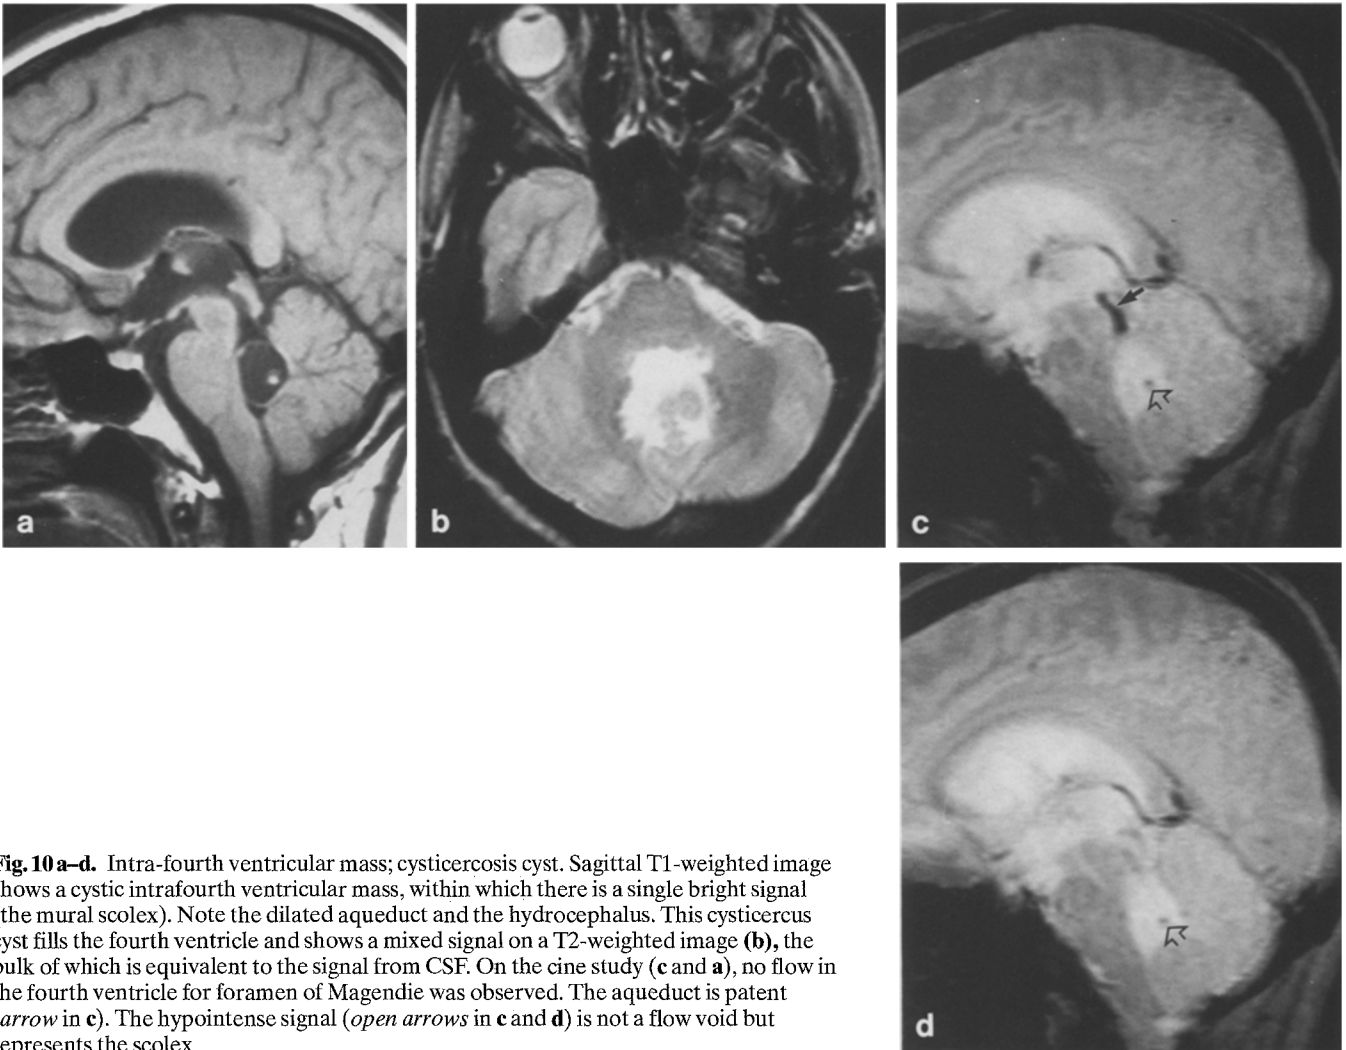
a–d. Intra-fourth ventricular mass; cysticercosis cyst. Sagittal T1-weighted image shows a cystic intrafourth ventricular mass, within which there is a single bright signal (the mural scolex). Note the dilated aqueduct and the hydrocephalus. This cysticercosis cyst fills the fourth ventricle and shows a mixed signal on a T2-weighted image (b), the bulk of which is equivalent to the signal from CSF. On the cine study (c and a), no flow in the fourth ventricle for foramen of Magendie was observed. The aqueduct is patent (arrow in c). The hypointense signal (open arrows in c and d) is not a flow void but represents the scolex
